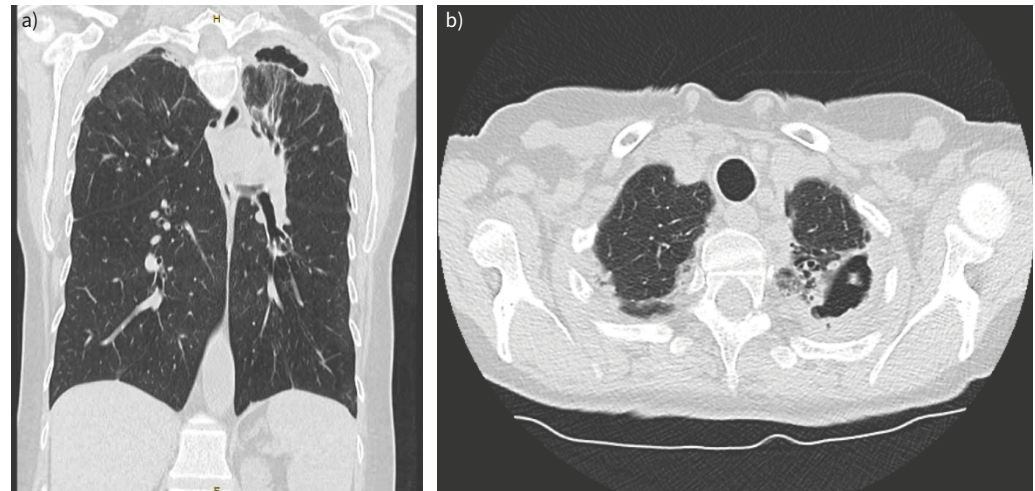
Computed tomography (CT) of the chest in 2014 (clinical scenario 2). a) The coronal view reveals a thick-walled cavity at the left apex, left upper lobe fibrosis and retraction. b) The axial view reveals debris in the left apical cavity, with adjacent peribronchial thickening.
